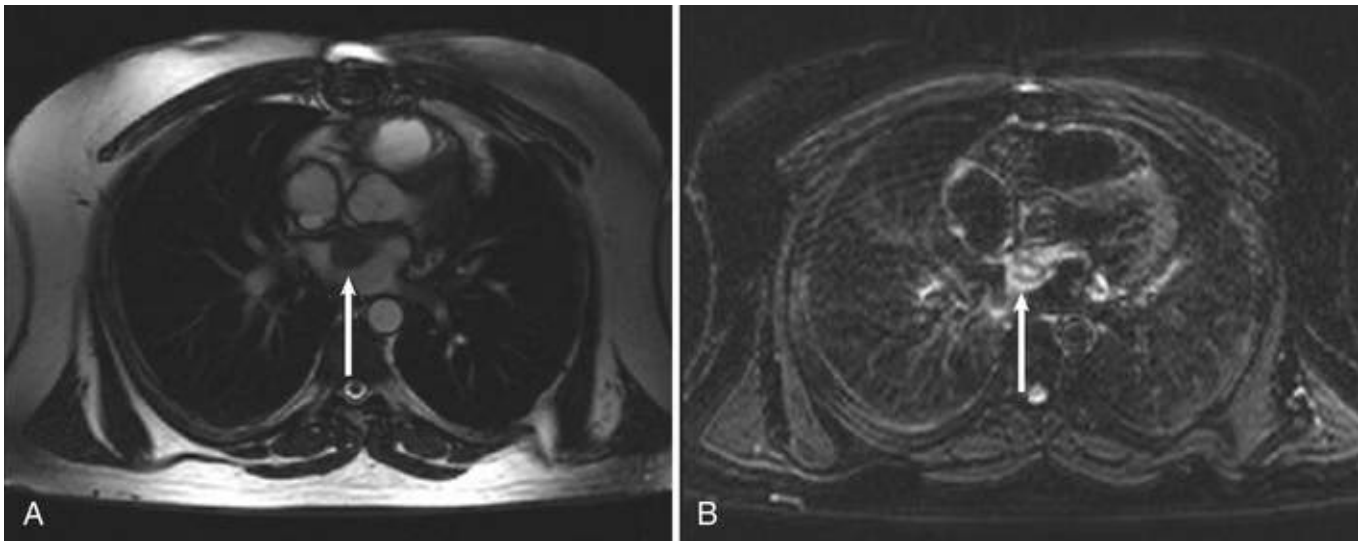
MRI imaging of a left atrial sarcoma. A, T₂-weighted cardiac MRI demonstrating a large left atrial mass near the anterior leaflet of the mitral valve. B, Brisk enhancement during first-pass perfusion of the mass confirms a high degree of blood flow, strongly suggesting an angiosarcoma.
